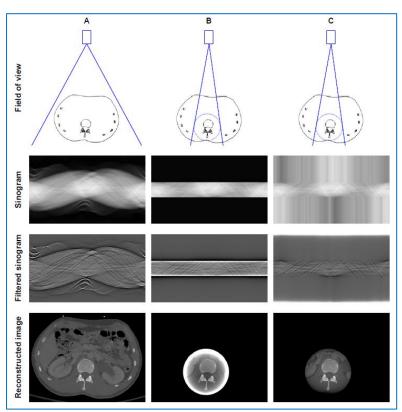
Top row shows the different fields of view, second row shows the corresponding sinograms, third row shows filtered sonograms and bottom row shows FBP reconstructions. Fist column (A) corresponds to a complete FOV acquisition, second column (B) Corresponds to a limited FOV in which the sinogram outside the FOV is set to zero, resulting in bright shading artifact. Finally, third column (C) presents a limited FOV, with the sinogram outside the field of view set to the end values. In this way, discontinuities are prevented, avoiding the bright rim (Boas 2012).
